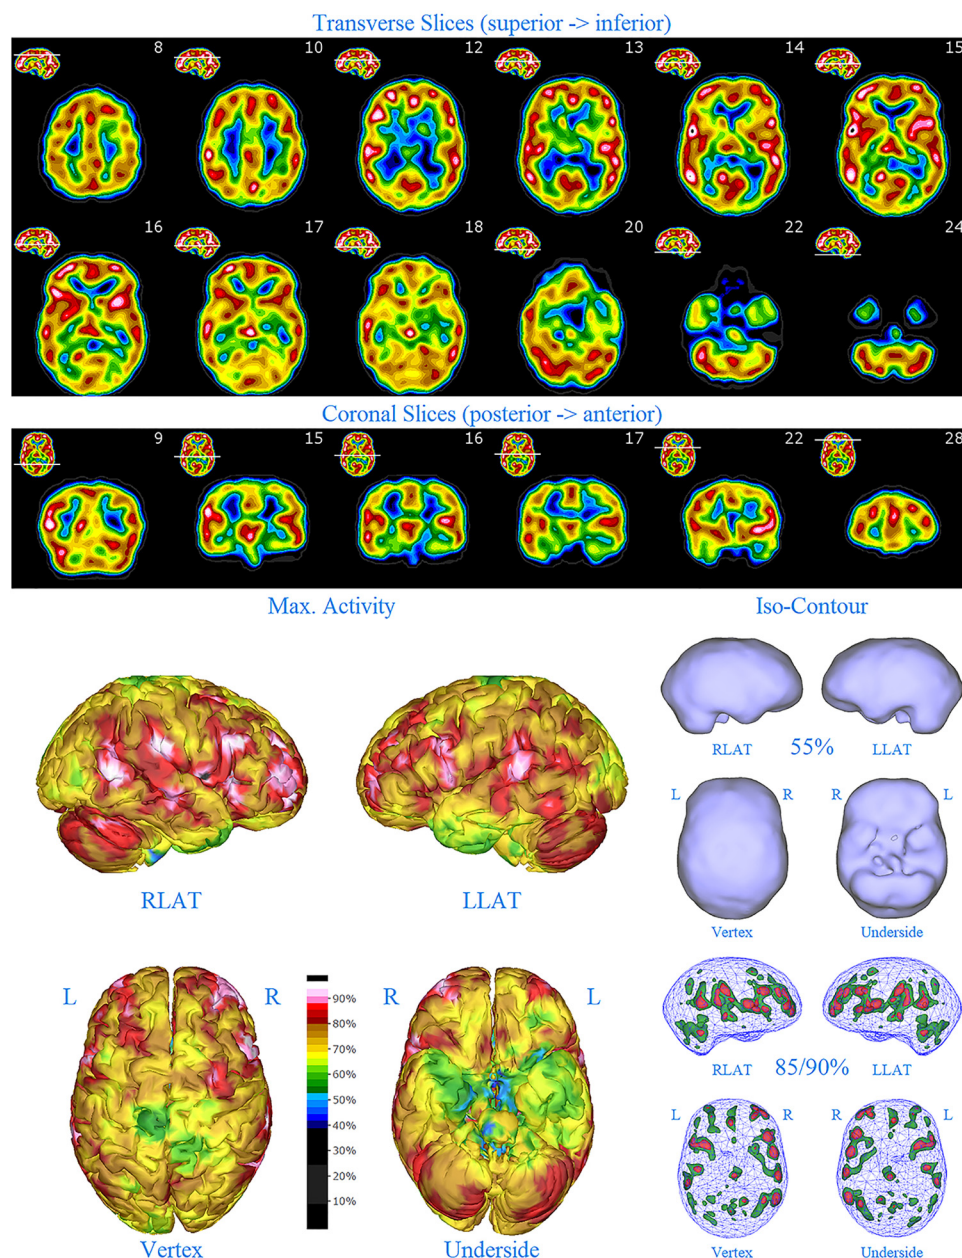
Second perfusion SPECT scan of Patient C. Arrangement, color scales, and views are identical to Figure 1. Anatomical structures such as the thalamus are positioned similarly to the scan shown in Figure 2. Labeling was eliminated to avoid obscuring the scan details. Perfusion of the thalamus is increased and asymmetrical. Multiple areas of markedly increased perfusion are found throughout the cerebral cortices. Also, areas of cortical hypoperfusion can be seen in the parietal cortices bilaterally (green on the 3-dimensional reconstruction).
